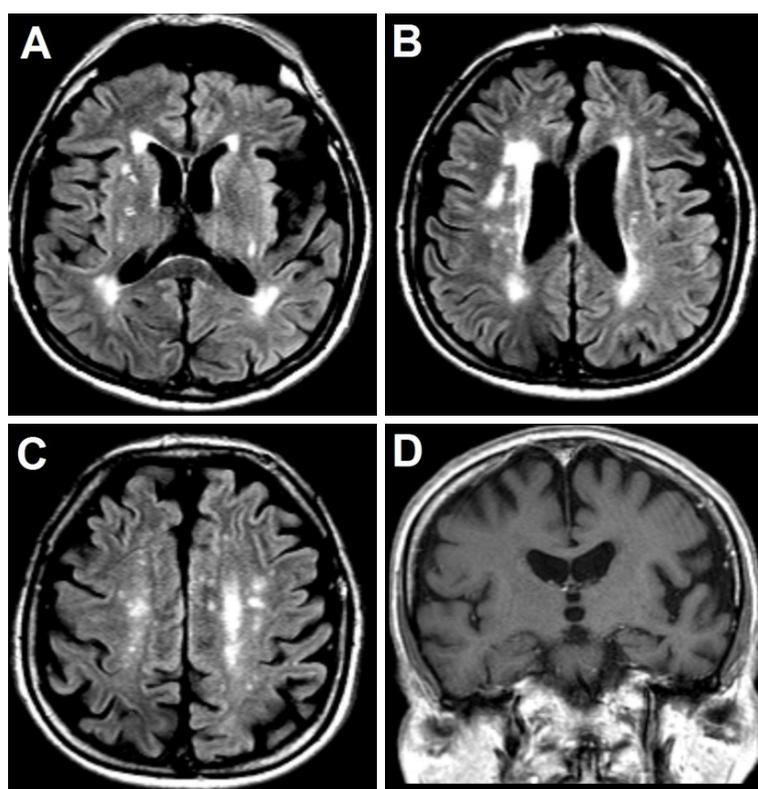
Brain magnetic resonance imaging of case 3. Fluid-attenuated inversion recovery images (A, B, C) show ischemic lesion load and frontal, perisylvian and frontoparietal atrophy more evident in the left hemisphere. In coronal T1 section (D), the hippocampus is preserved
